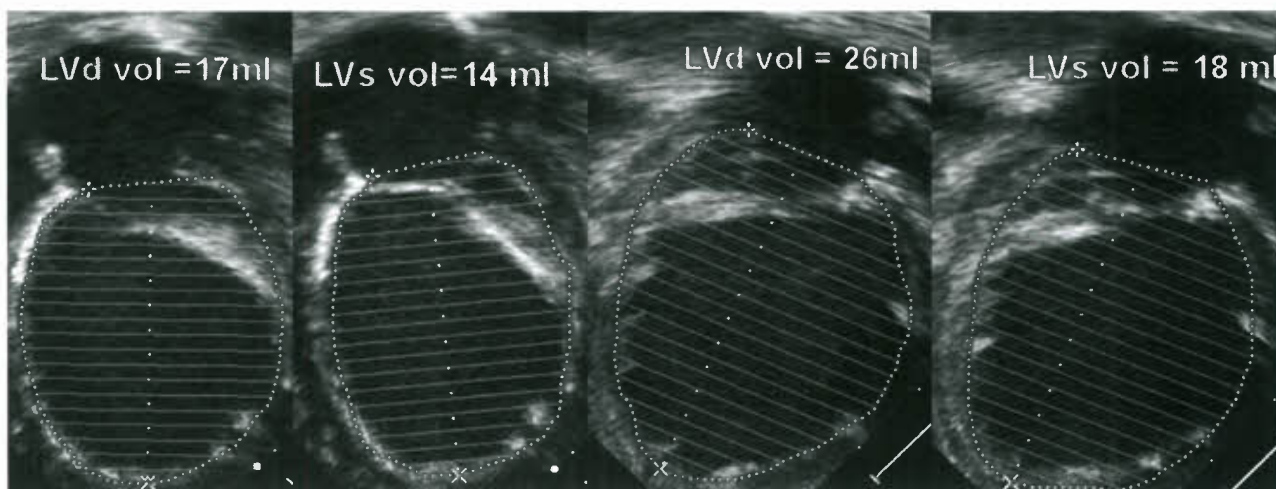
Use of biplane Simpson's rule in calculating left ventricular (LV) volume in patients with severe LV dysfunction. The first two images from the left show the apical four-chamber view in end diastole and end systole, respectively. The next two images are obtained from the apical two-chamber view also in end diastole and end systole, respectively. LV volumes in end diastole and end systole can be calculated. Based on the biplane measurements, the LV ejection fraction in this example is 22%.
